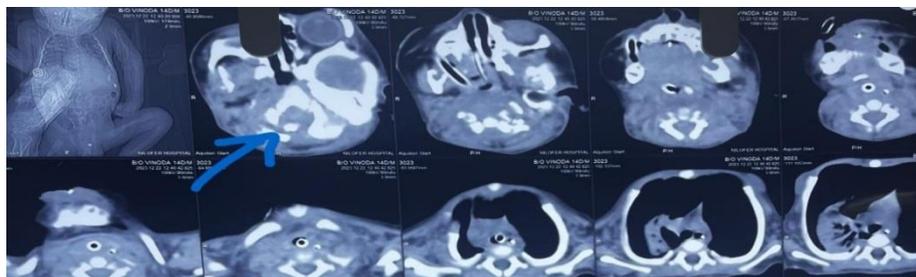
Contrast-enhanced computed tomography of the head and spine indicating capitalization of the atlas with basilar invagination
